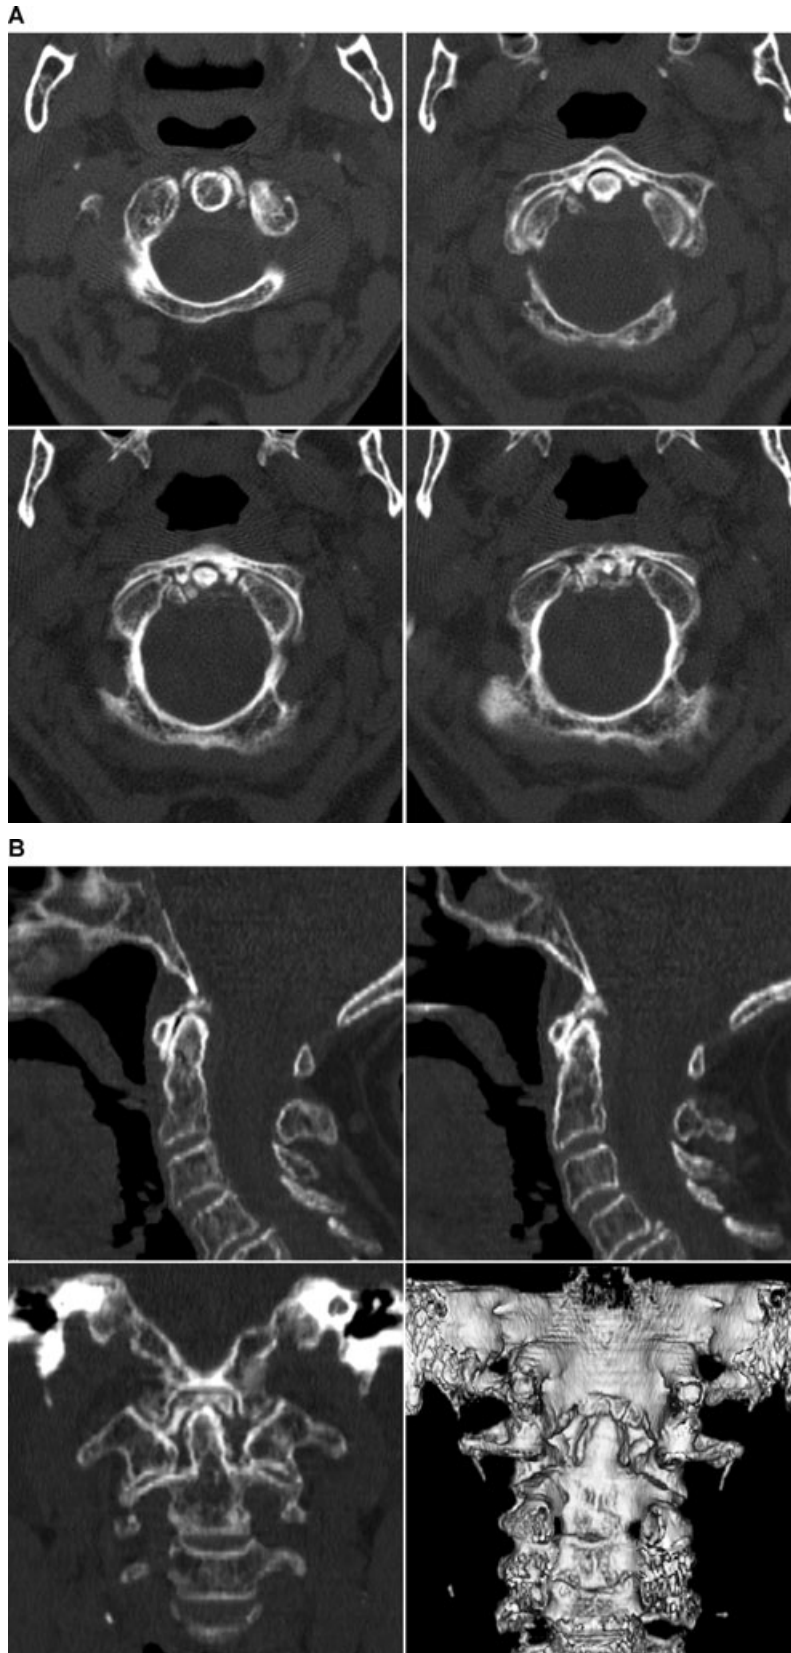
Axial CT scans at C1-C2 level (A) in an asymptomatic 75-year-old woman showing calcified deposits lateral and superior to the odontoid process and degenerative changes of the atlanto-axial joint characterized by gas within the joint space, subchondral sclerosis, and marginal osteophytes. Reformatted images in the sagittal (B, upper row) and coronal (B, lower left image) planes disclose even more clearly the crown-like periodontoid calcifications and the atlanto-axial degenerative changes, also shown in a volume-rendered 3-dimensional reconstruction (B, lower right image). A reformatted sagittal image with inverted window (C) reveals a noncalcified retro-odontoid soft tissue component.
